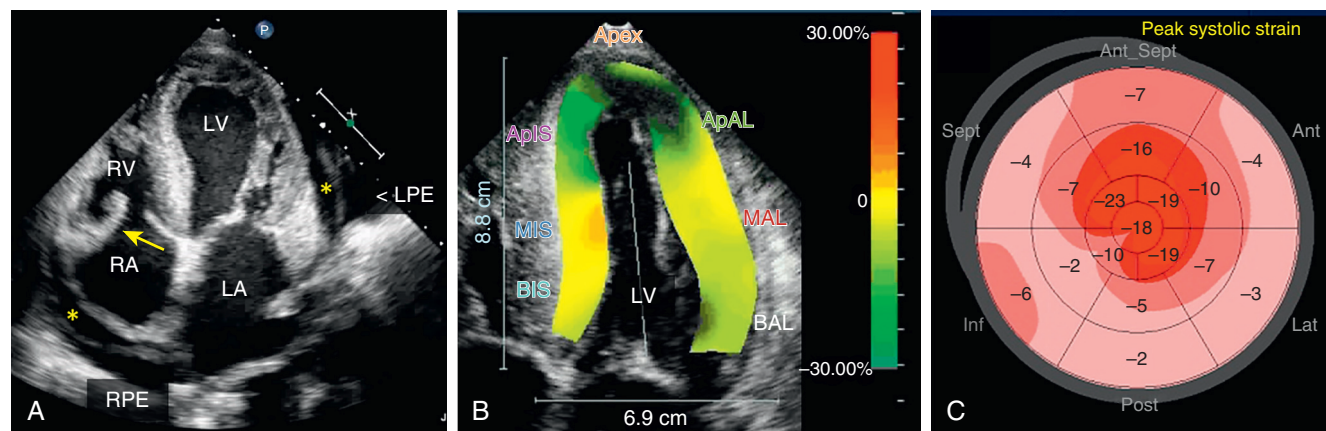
Two-dimensional echocardiography and strain imaging of amyloidosis. A, Transthoracic echocardiogram in the apical 4-chamber view demonstrates typical features of amyloidosis: increased left ventricular (LV) and right ventricular (RV) wall thickness, bi-atrial enlargement, thickened valves (arrow), pericardial effusion (asterisk), and pleural effusions. B and C, Speckle-based longitudinal strain imaging demonstrates the phenomenon of apical sparing (relative preservation of apical longitudinal strain in the setting of otherwise decreased LV longitudinal strain). Global longitudinal strain in this patient was diminished to -10% (see corresponding Video 178.4, A and B). LA, left atrium; LPE, left pleural effusion; RA, right atrium; RPE, right pleural effusion.
